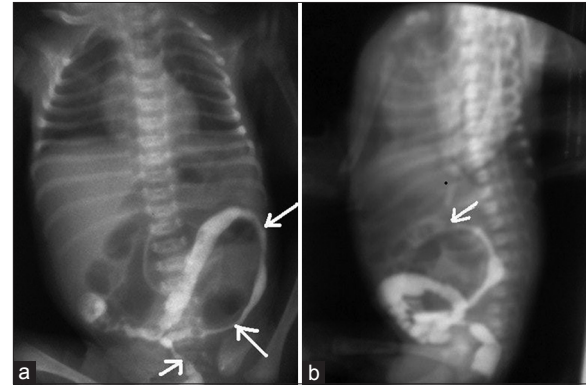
(a) Gastrografin contrast enema in separate sitting shows the narrow segments of descending colon and the part of sigmoid colon (white arrows). (b) Lateral radiograph of the abnormal narrowed segment can be seen extending till splenic flexure (white arrow)
